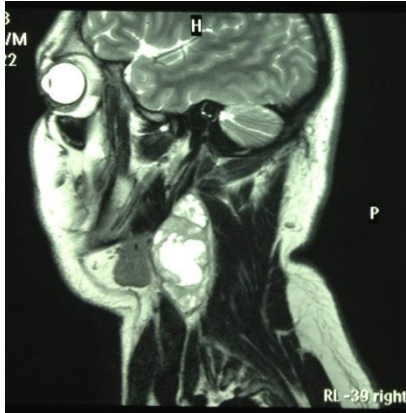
MRI of the cervical region was solicited and revealed expansive solid tumor with foci of heterogeneity in the inner compatible with cystic degeneration.
